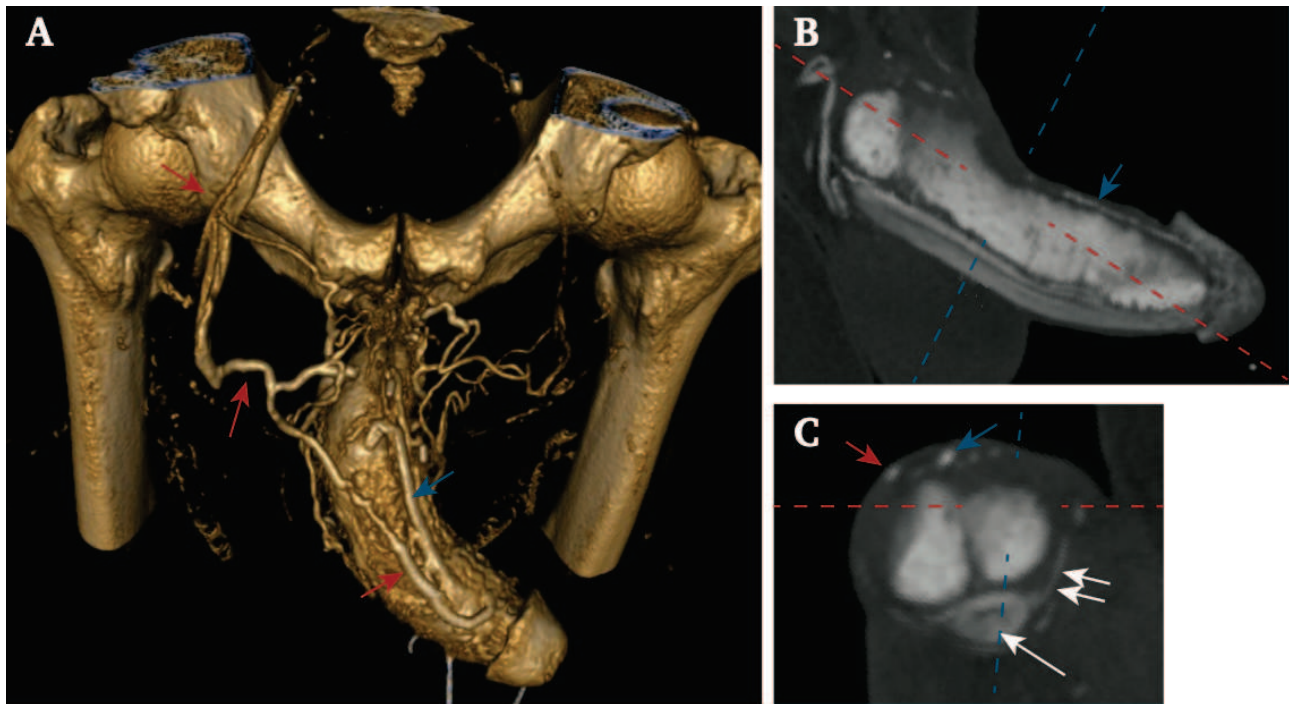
Leaks between CC and CS [modified from Allaire (2021) et al. and vizua software] 3D reconstruction by VRT Pharmacologically challenged computed caverno-CT pre-operative analysis of leakage pattern in (A) volume rendering, (B) longitudinal, and (C) transversal views demonstrating superficial leakage through abnormal vein (red arrows), deep dorsal vein (blue arrows), abnormal opacification of the spongiosa corpus due to cavernospongious fistula (single white arrow; B), and circumflex vein responsible for spongiosa corpus leakage (double white arrow; C) in a patient with drug resistant erectile dysfunction caused by cavernovenous leakage.
